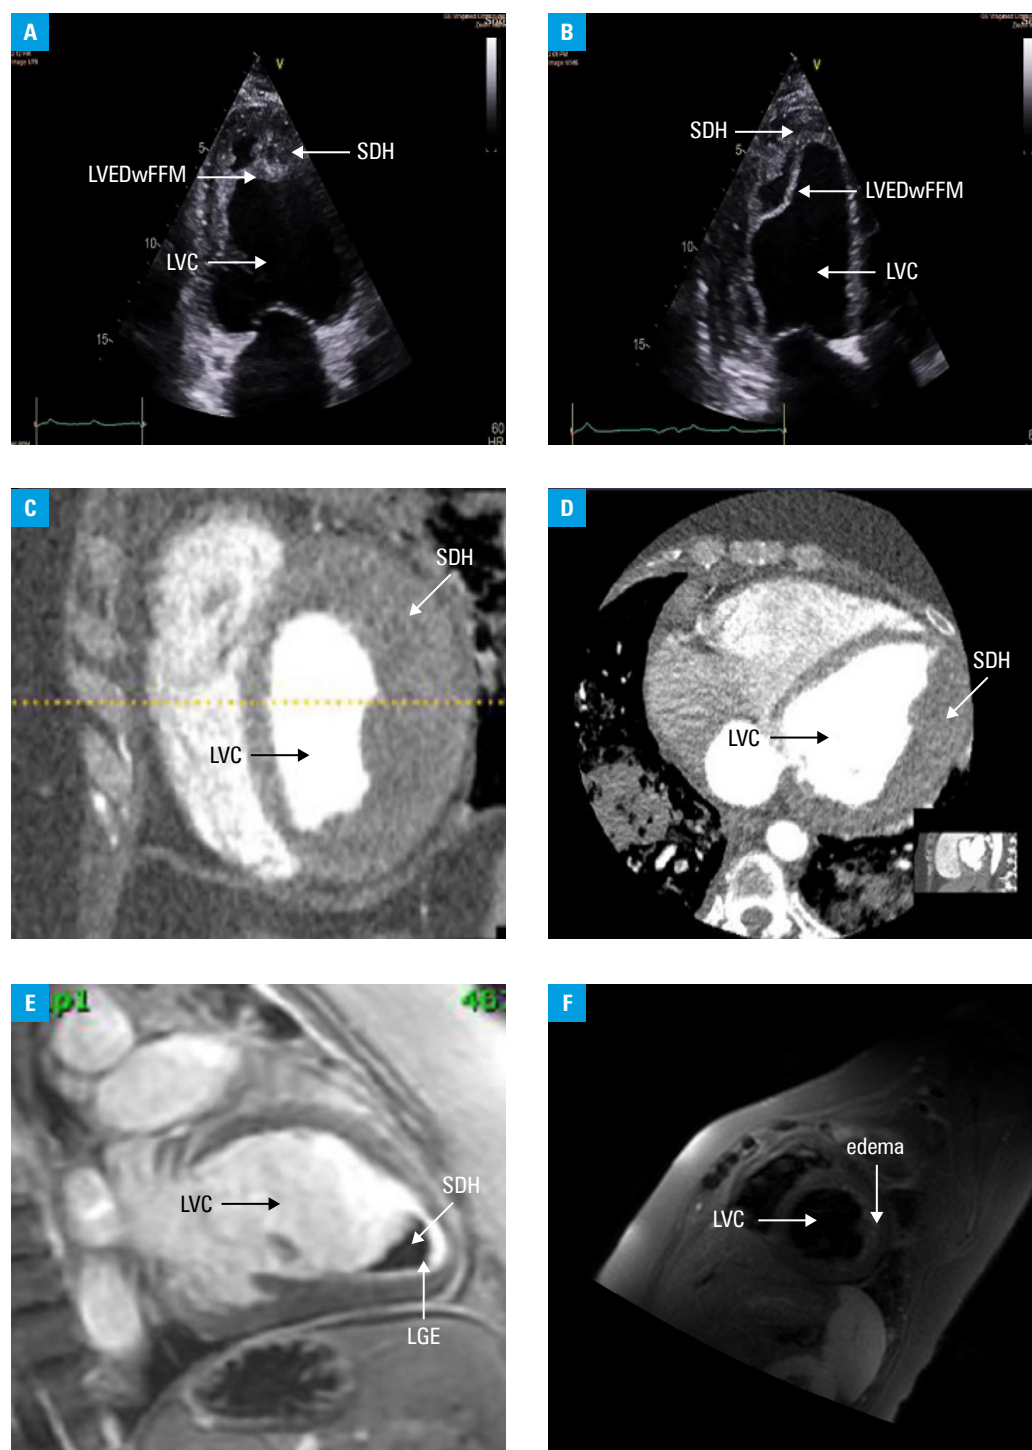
A, B – transthoracic echocardiography visualizing an intramyocardial dissection of the anterolateral left ventricular wall with the formation of a space containing hematoma; modified 2-dimensional apical view during diastole (A) and systole (B); C, D – computed tomography angiography images showing a massive subendocardial dissecting hematoma (C – short axis view; D – 4-chamber axial view); E – magnetic resonance imaging showing the subendocardial dissecting hematoma and late gadolinium enhancement (2-chamber view during systole); F – magnetic resonance imaging showing a T2-sequence abnormality—edema (short axis view during systole)
